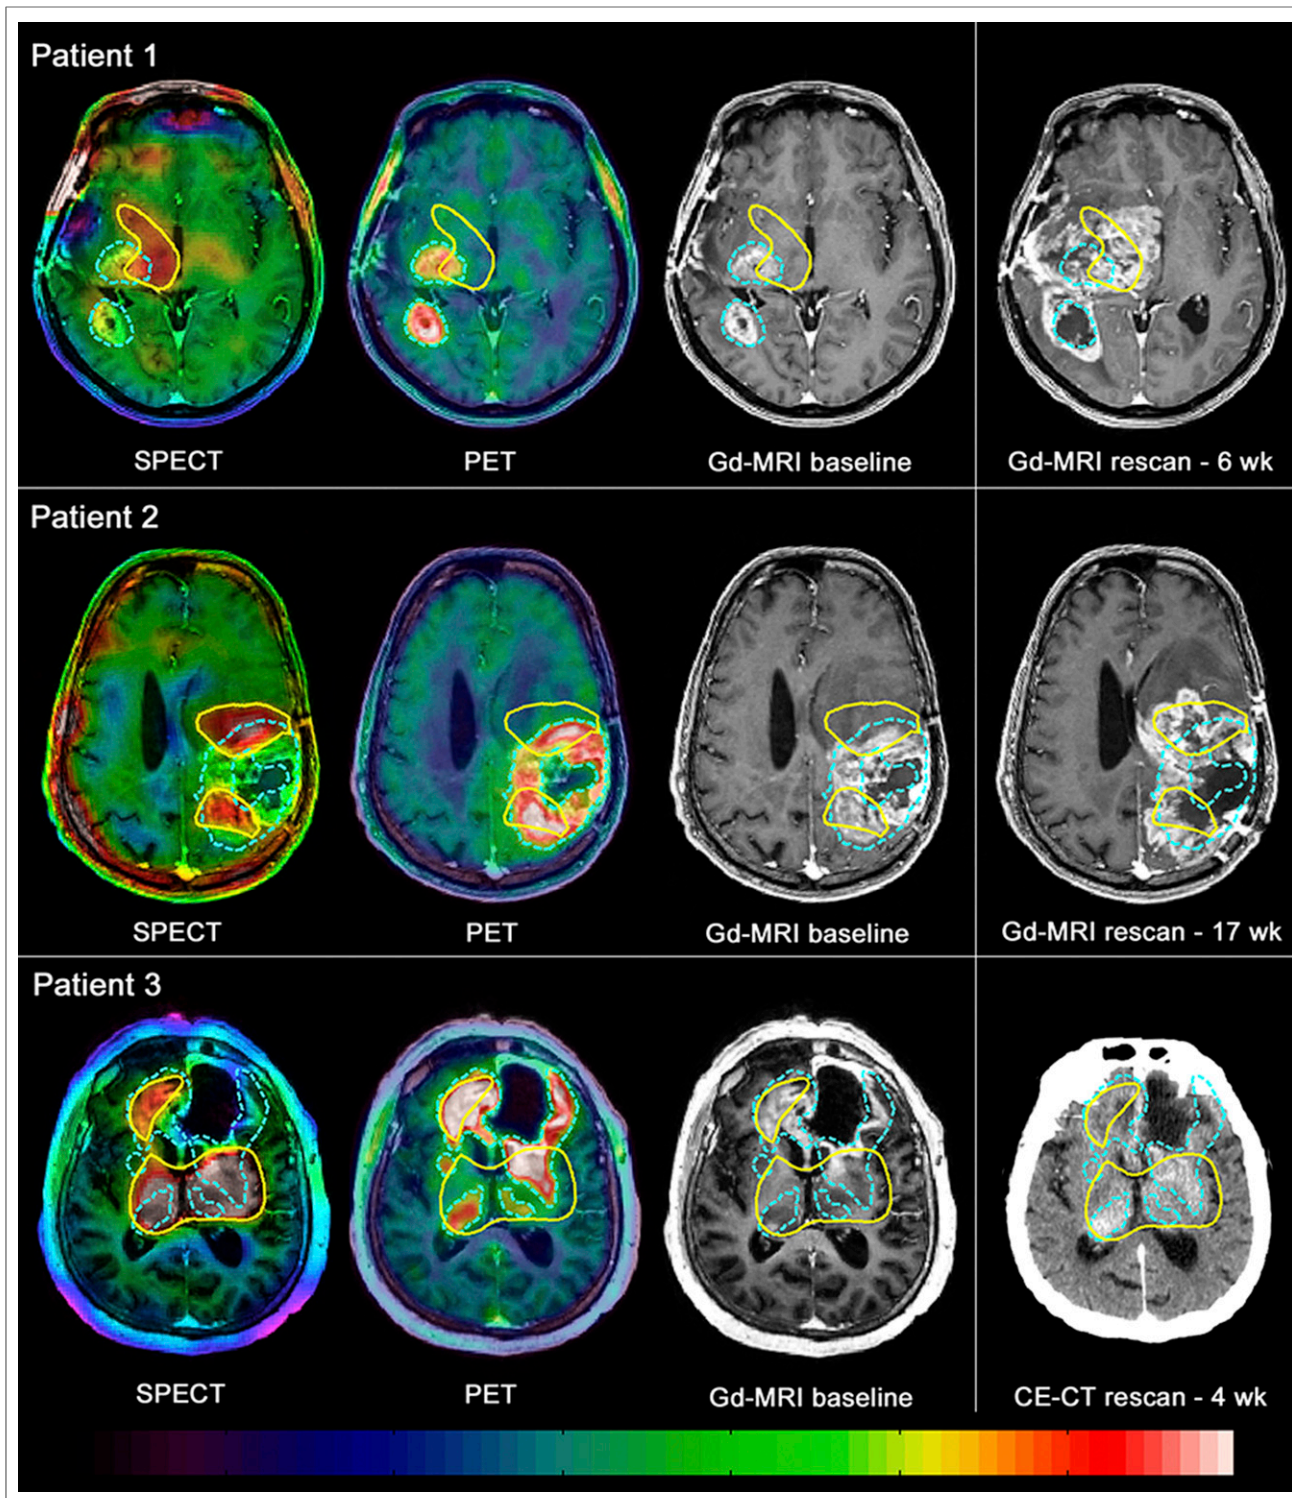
Weighted mean 0- to 150-min ^{123}I -CLINDE SPECT scans, summed 20- to 40-min ^{18}F -FET PET scans, and gadolinium- or contrast-enhanced (CE) structural scans at baseline and at rescanning. Blue VOIs show high ^{18}F -FET tumor uptake, and yellow VOIs high ^{123}I -CLINDE binding. Comparison of baseline and rescanning structural scans reveals that tumor expands predominantly in areas of high ^{123}I -CLINDE binding.
